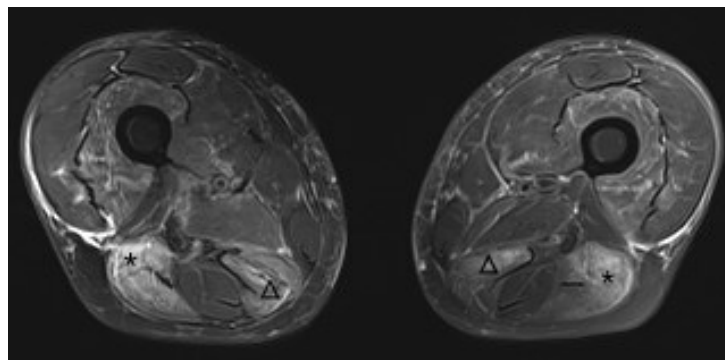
MRI, axial T2-weighted sequences (fat sat TSE) of both thighs revealed edema in the musculus quadriceps, musculus adductor magnus and the hamstrings, most prominent in the musculus semimembranosus (indicated by Δ) and the musculus biceps femoris (indicated by *).
